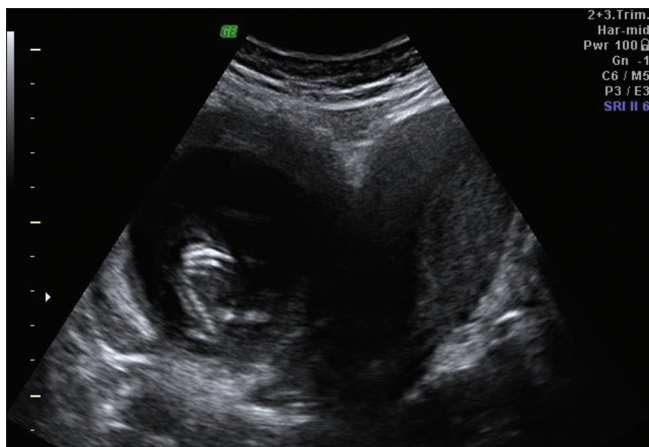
An ultrasound image demonstrating two uterine cavities indicating to either a left-sided nonpregnant unicornuate uterus with a pregnant right-sided rudimentary horn or a right-sided pregnancy in a bicornuate uterus. No fetal cardiac activity was seen
